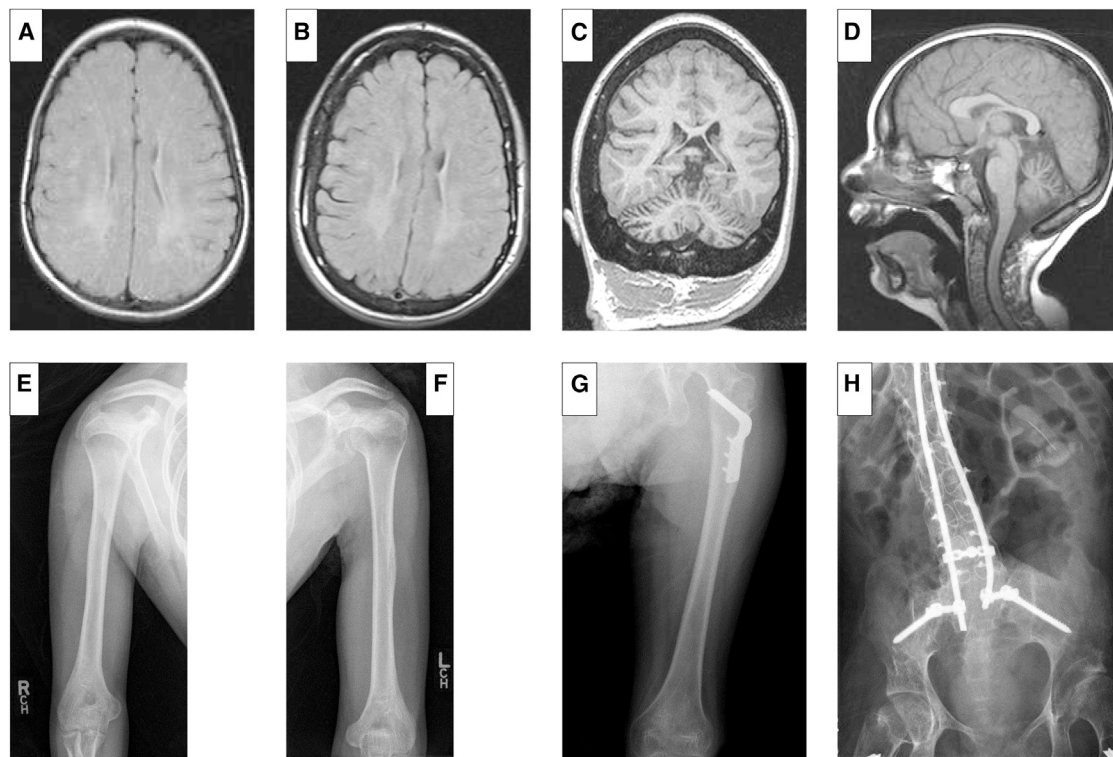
MRI Pictures and X-Rays of Individual II-1 from Family B
